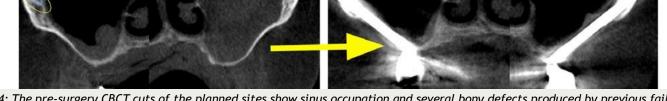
The pre-surgery CBCT cuts of the planned sites show sinus occupation and several bony defects produced by previous failed grafting and implants. The transparent one-year post-surgery CBCT cuts indicate an excellent response to the used ZAGA surgical protocol in combination with ZAGA zygomatic implants.
